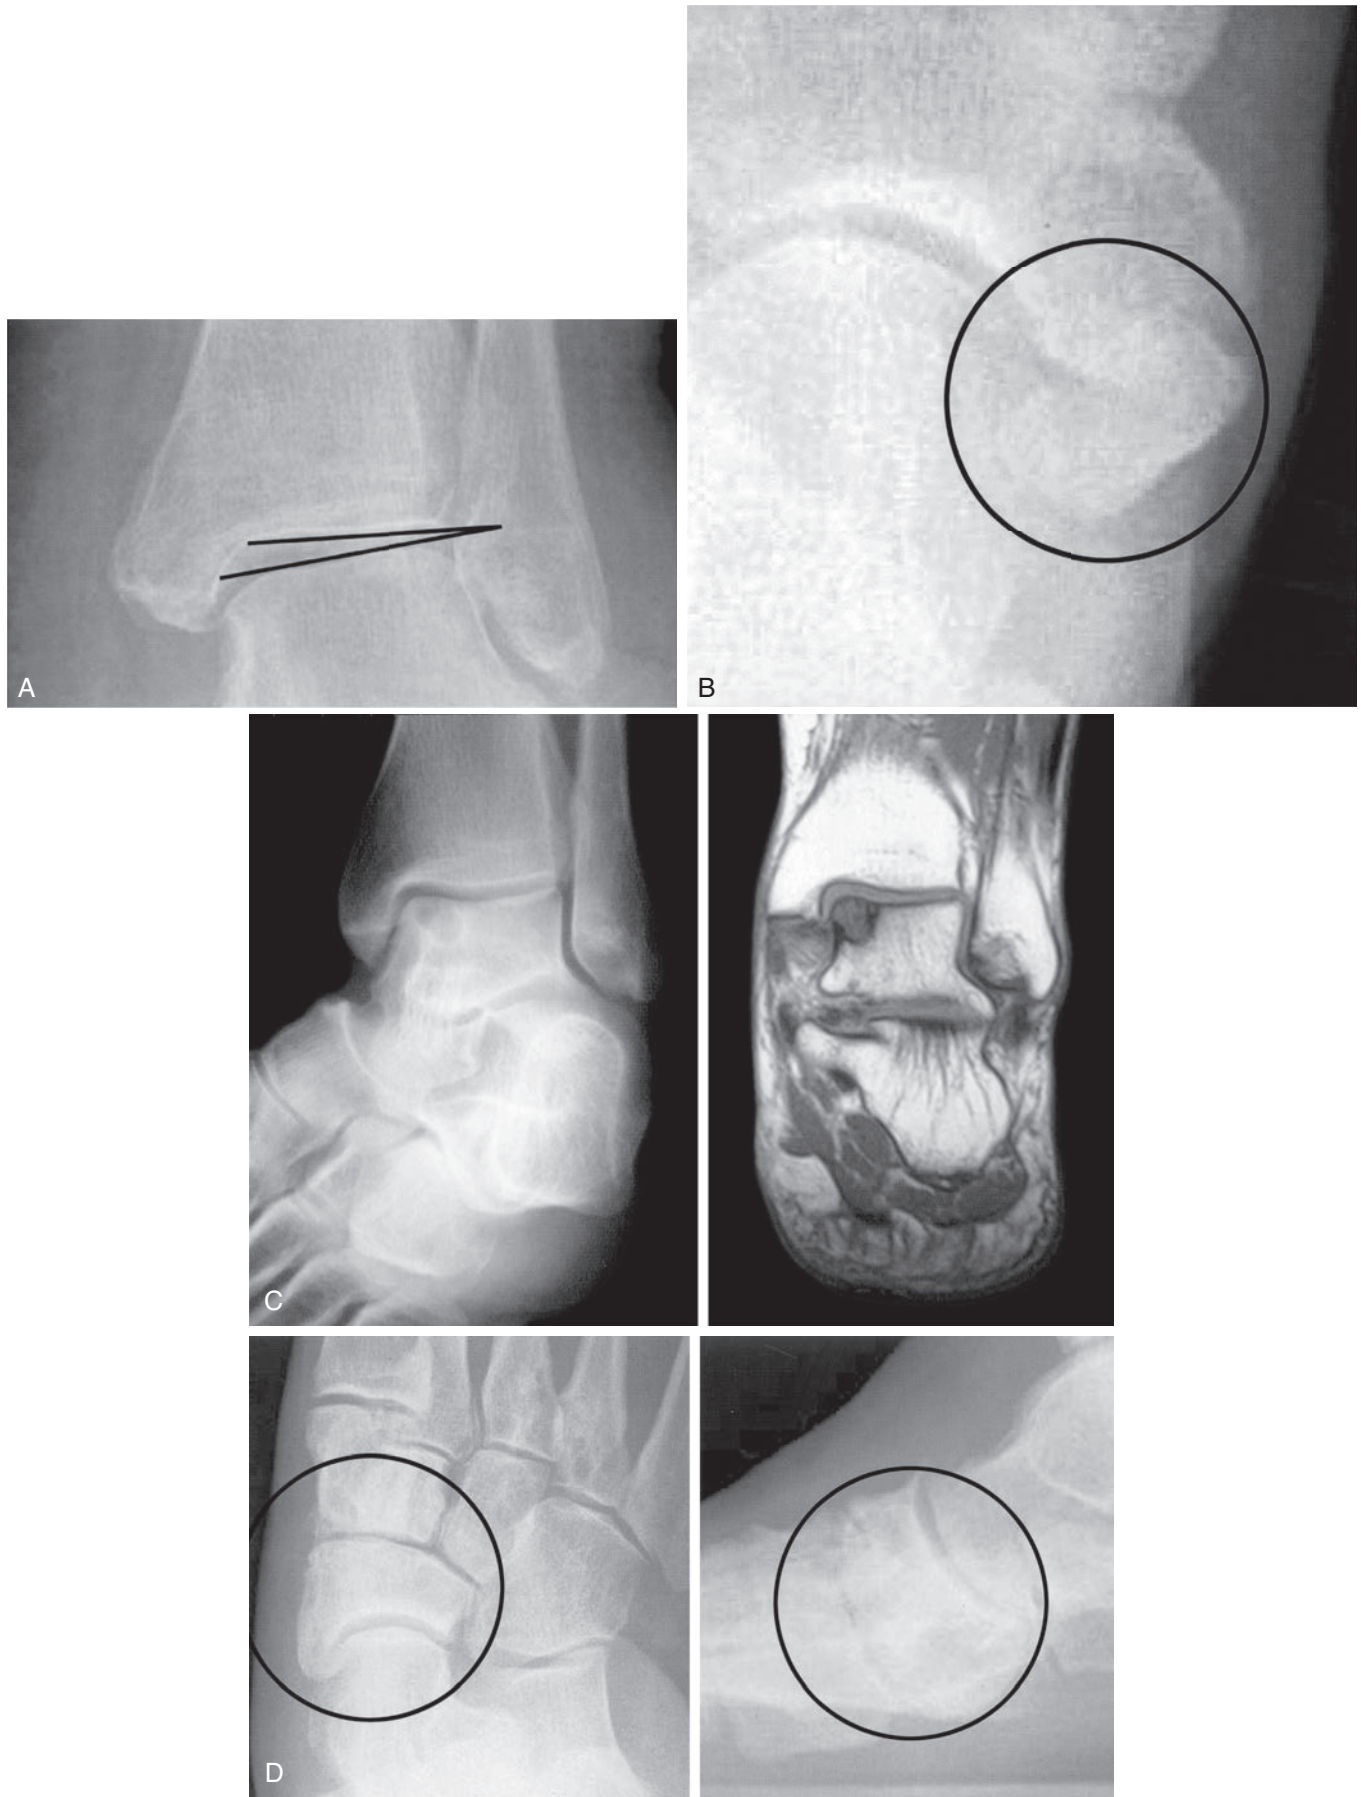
Radiographs of patients with medial ankle or midfoot pain and swelling demonstrating medial talar tilt because of primary deltoid ligament incompetency (A) accessory navicular (B) medial talar dome osteochondritis dissecans with a coronal magnetic resonance imaging (MRI) view (C) and medial column arthritis. (D) All of which can mimic to varying degrees the clinical presentation of posterior tibialis tendon dysfunction.
